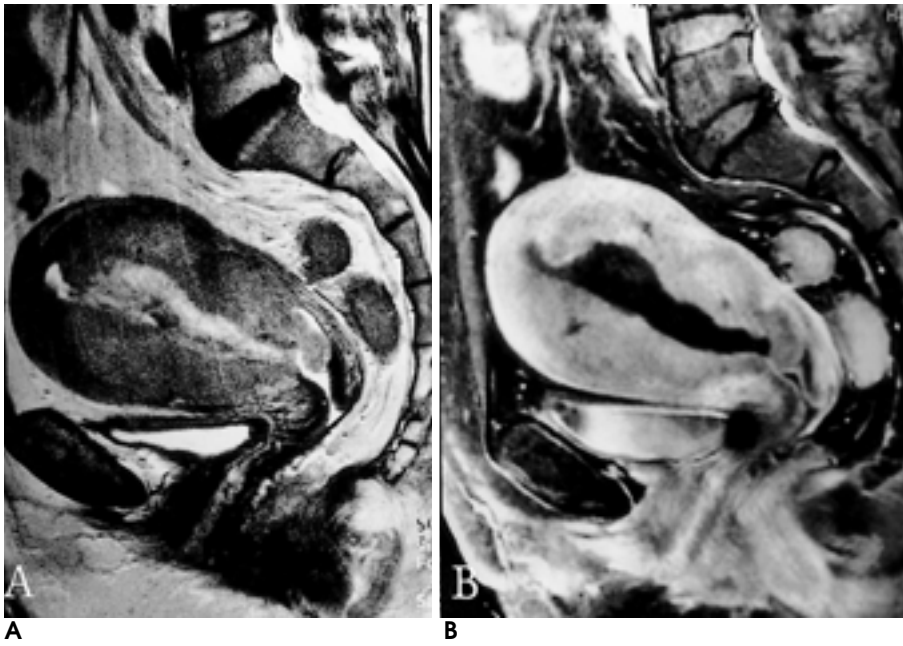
Endometrial carcinoma involving endometrium and myometrium shows invasion of the uterine endocervix on axial T2-weighted image(A) and fat-suppressed Gd-enhanced T1-weighted image(B).
